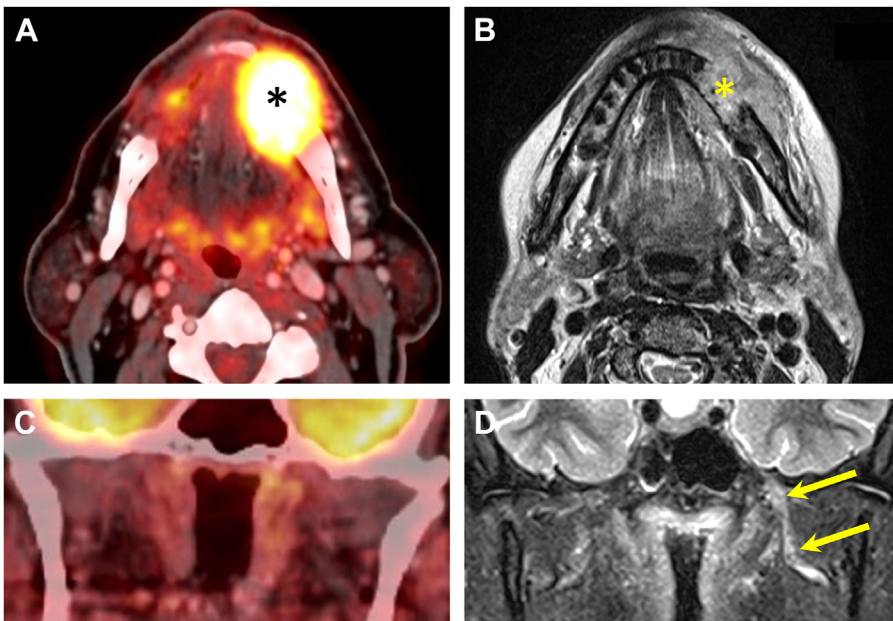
(A, C) PET/CT images. (B, D) Corresponding MR imaging obtained in the same patient with SCC of the oral cavity (asterisks) invading the horizontal branch of the mandible. SUV_{max} , 18. The coronal PET/CT image (C) does not show any PNS along the mandibular nerve (V3). However, the corresponding coronal Short-T1 Inversion Recovery (STIR) image (D) clearly shows thickening of V3 (arrows) extending up to the foramen ovale and corresponding to PNS. After IV administration of contrast material, enhancement of the thickened V3 was seen (not shown). Six months after surgery and radiochemotherapy, PNS progressed intracranially.
